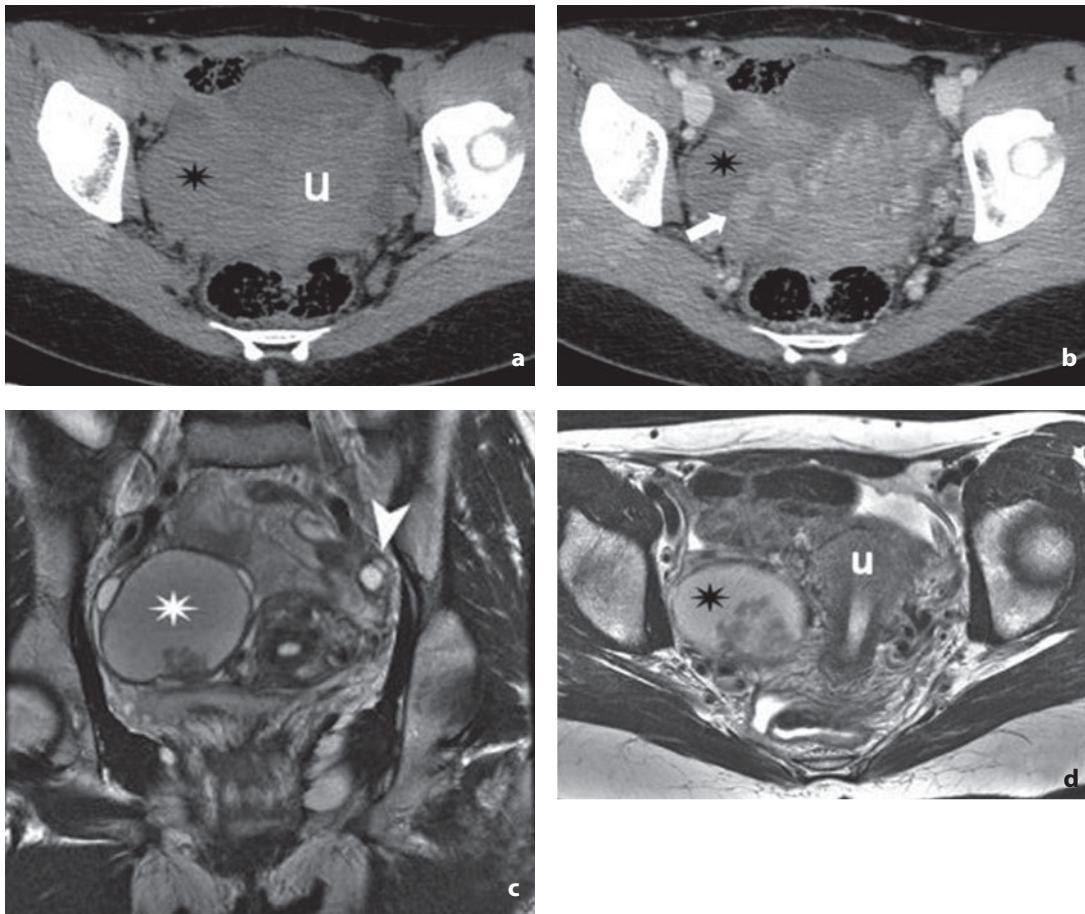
Computed tomography and magnetic resonance. Borderline endometrioid adenocarcinoma in endometrial cyst. a Nonenhanced CT. Expansive and weakly hyperattenuating right adnexal mass (*asterisk*). b After contrast medium administration a nonenhancing cystic component (*asterisk*) can be identified associated with intensely enhancing mural nodules (*arrow*). c Coronal T2-weighted MR image shows the right adnexal origin of the lesion (*asterisk*) with healthy ovarian parenchyma compressed in the periphery. The contralateral ovary (*arrowhead*) can also be identified without lesions. (*cont.* →)
